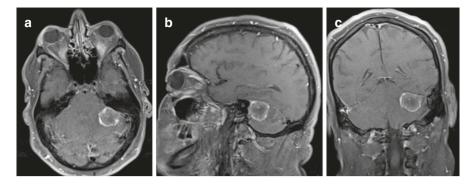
MRI Brain: (a). Axial T1 image with contrast; (b). Sagittal image with contrast; (c). Coronal image with contrast
